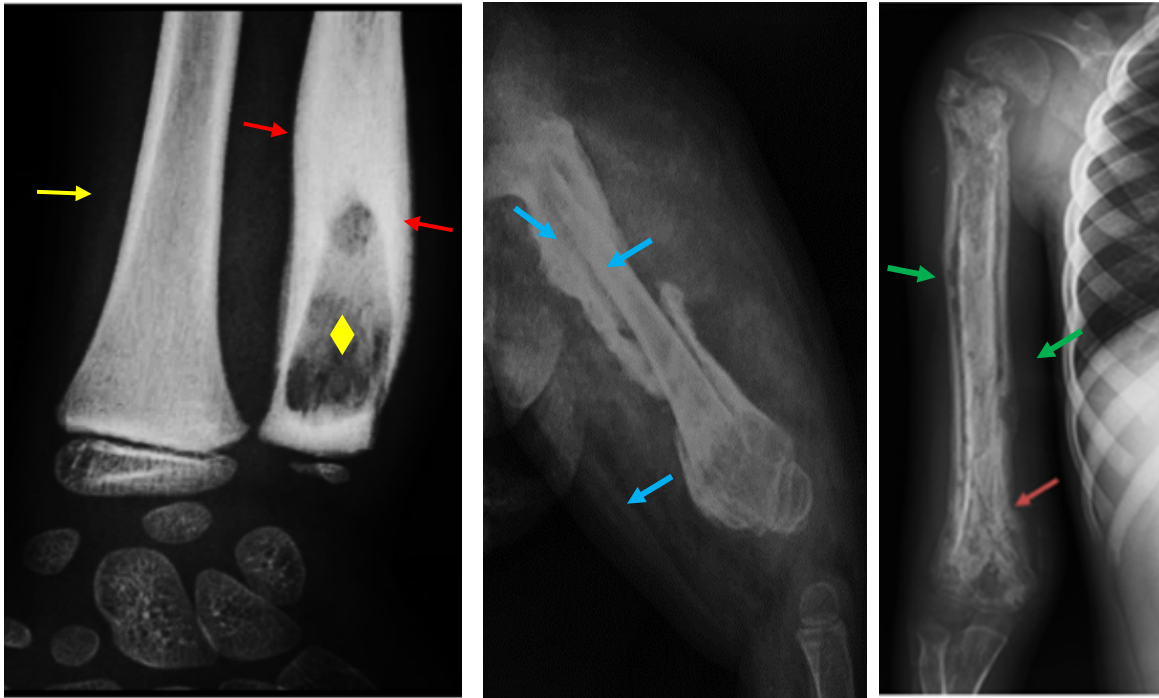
8 years, SAOM of the left ulna, day 20. Radiography of the left wrist.
